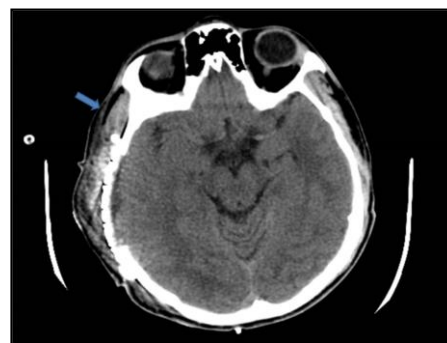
Postoperative CT scan showing complete clearance of tumour (arrowhead)
